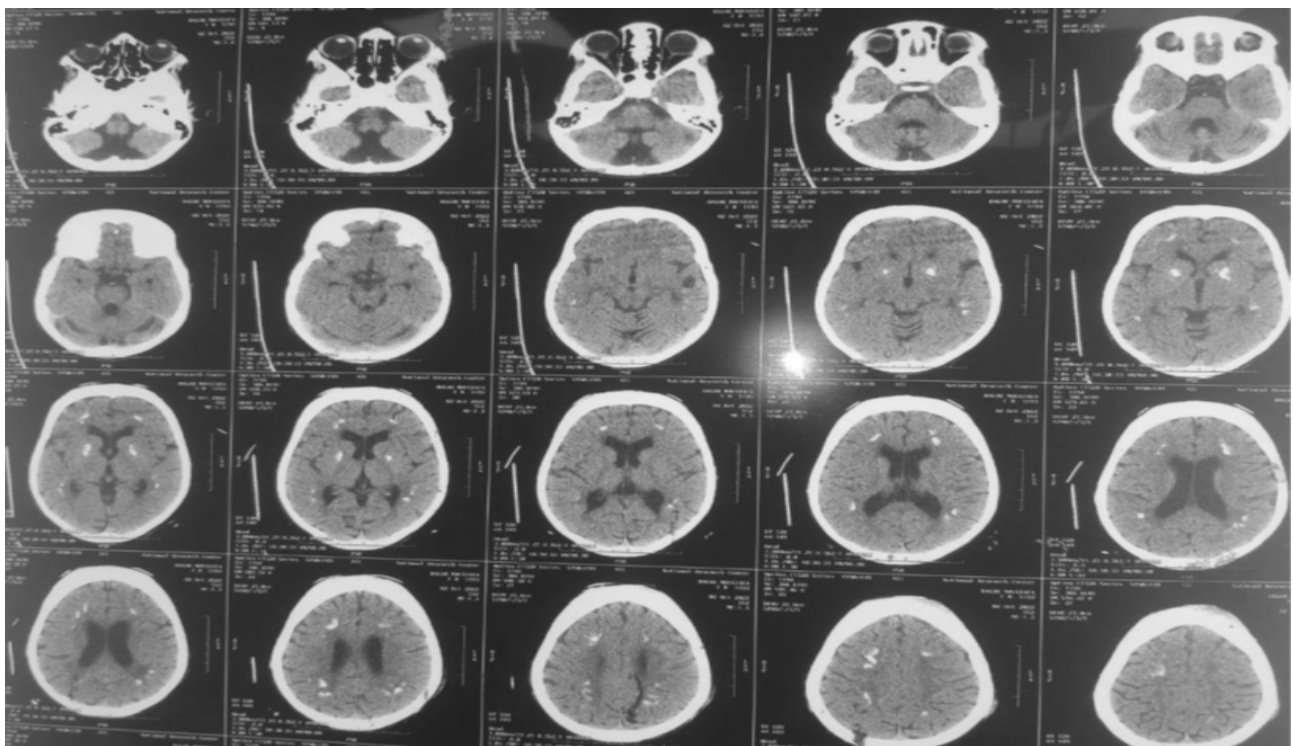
CT brain showing a bilateral small intracerebral calcifications; frontal, parietal lobes, and basal ganglia, together with frontal cephalhematoma. CT, computed tomography.
